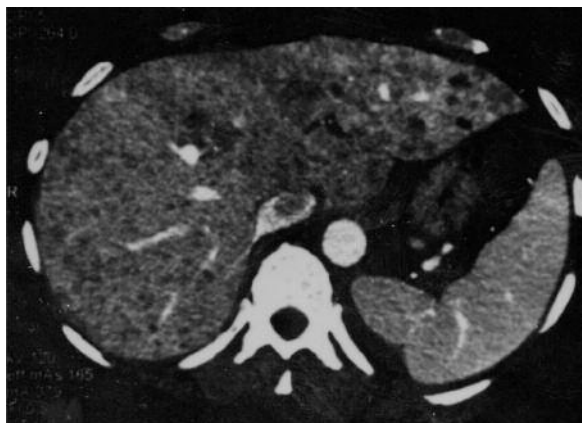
Contrast-enhanced abdominal CT scan showing innumerable, hypo-attenuating various-sized focal lesions of the liver.
